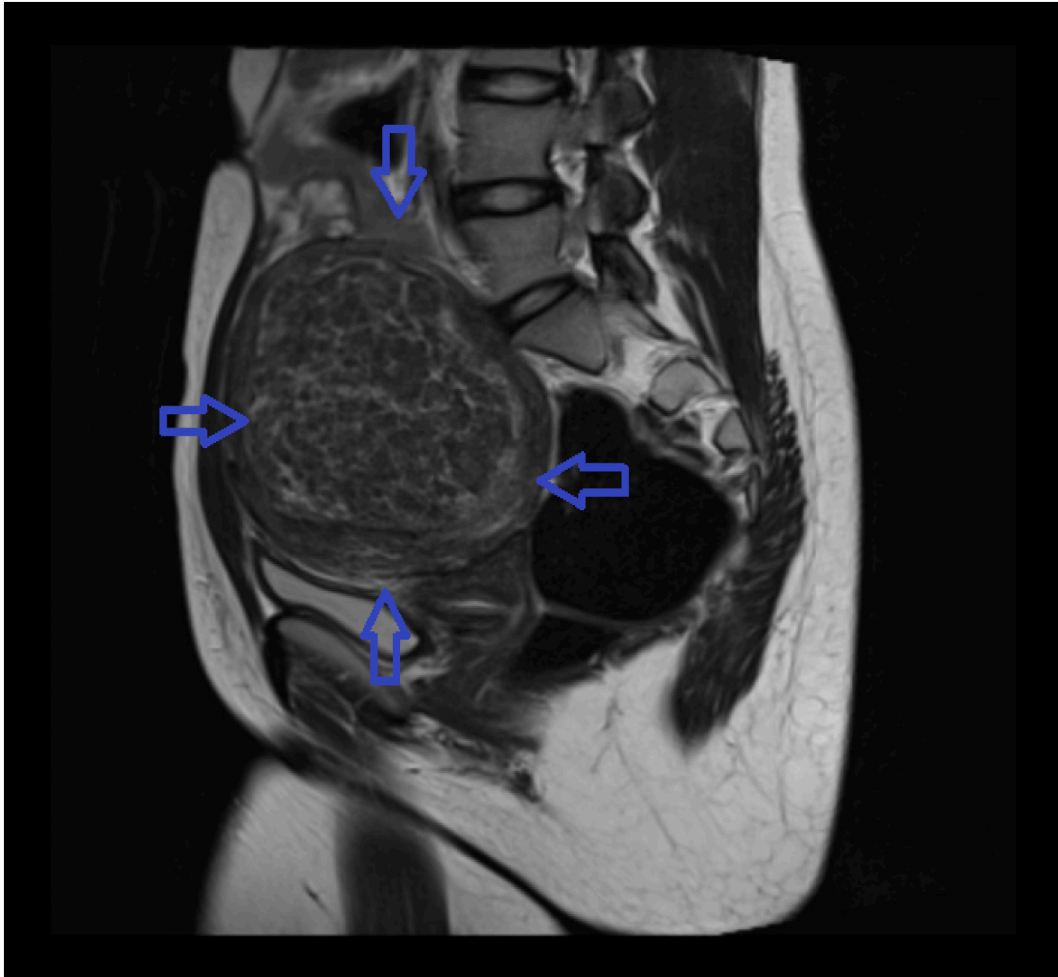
MRI sagittal view revealing a complex, heterogeneous lesion (indicated by the arrows) in the posterolateral intramural uterine wall measuring $10 \times 7 \times 9$ cm.
